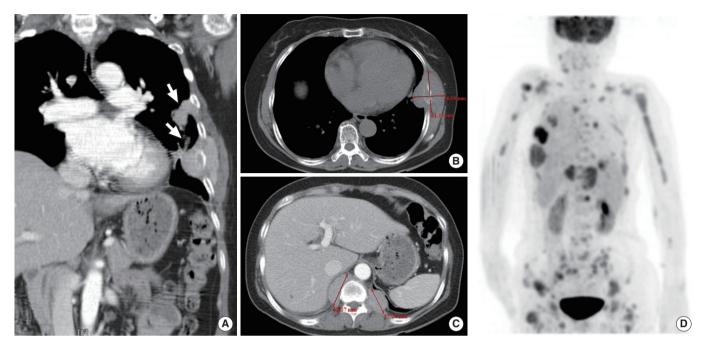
Imaging studies. Computed tomography (CT) and positron emission tomography (PET)/CT findings showing the branching out lung mass (A), pleural nodules (B), and paraspinal lesions (C), which were initially interpreted to be suggestive of lung cancer with bone destruction and metastasis. PET/CT reveals multiple hypermetabolic bone lesions (D).
